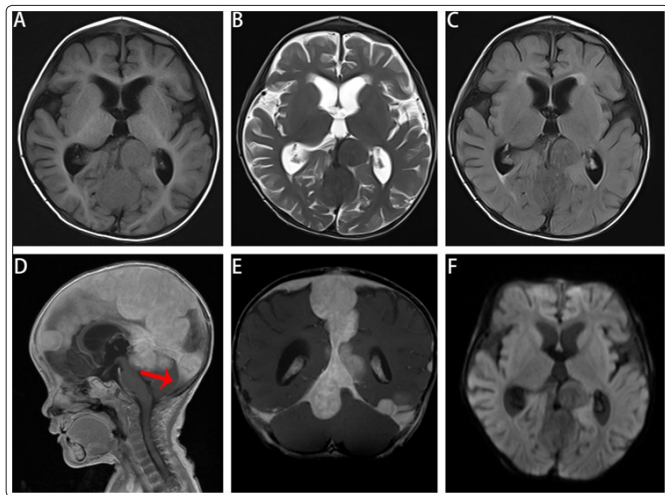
Multiple nodules along Dura with obvious enhancement, on Axial T1 weighted image (A) Showed iso-intensity to gray matter, on T2-weighted (B) showed hypo-intensity. Axial (C) fluid attenuation inversion recovery (FLAIR) T1 weighted MR image showed mild hypo intense lesion with respect to gray matter. Sagittal (D) and coronal (E) T1 post gadolinium enhanced images showed multiple avidly enhancing lesions with abnormal surrounding Dural thickening (red arrow). Coronal image shows internal carotid artery branch surrounded by lesions (red angle) and compressive inferior sagittalsinus (red thin arrow). Axial (F) diffusion-weighted MR image shows no significantly reduced diffusion with the lesion.
